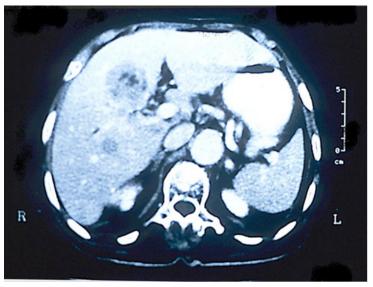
CT scan. Metastasis of segments IV and VII. Patient died from recurrence at 8months Archives of Gastroenterology and Hepatology V3.12.2020
